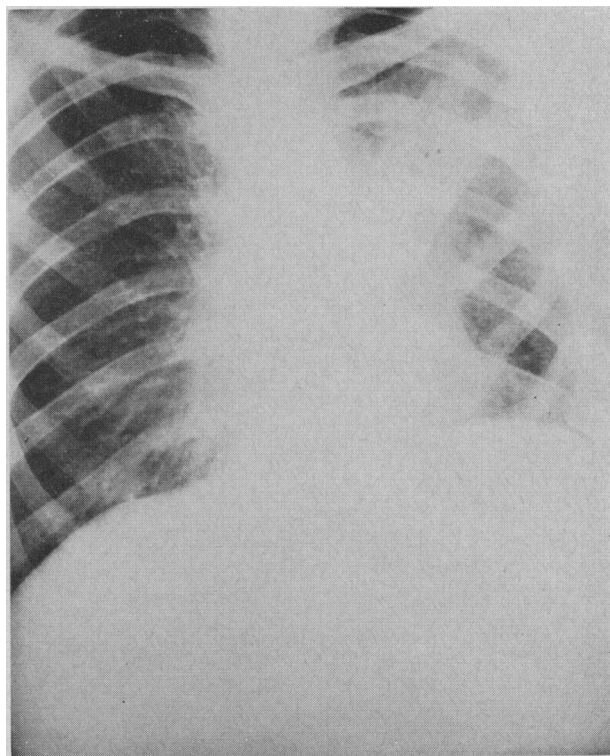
This radiograph shows new infiltration of the left upper lobe that occurred after the initial response to therapy. This was tuberculous in origin.
